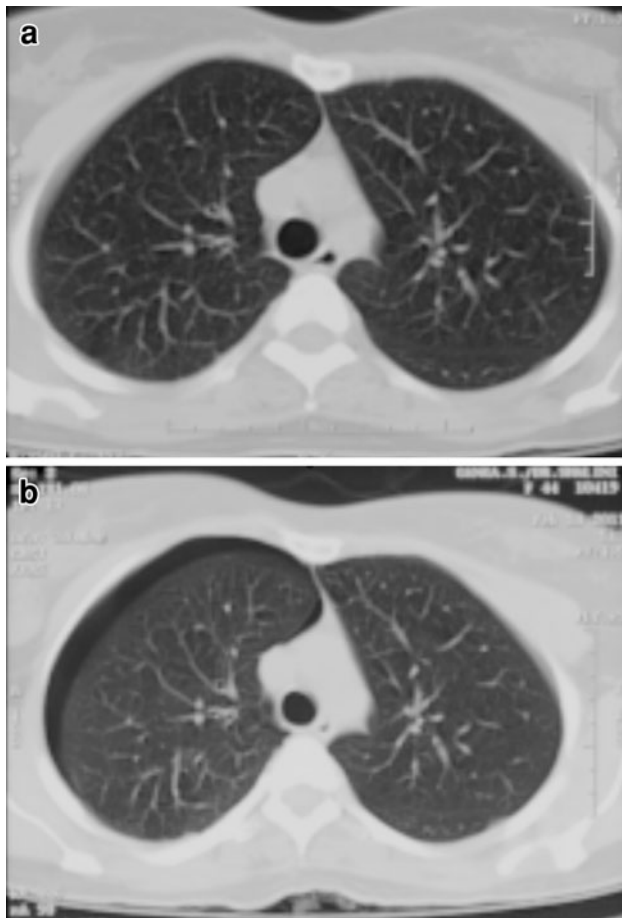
a Normal premenstrual, nonenhanced CT sections (lung window) taken at a level 1 cm above the carina. b CT sections taken during menstrual cycles showing right sided pneumothorax (1)
